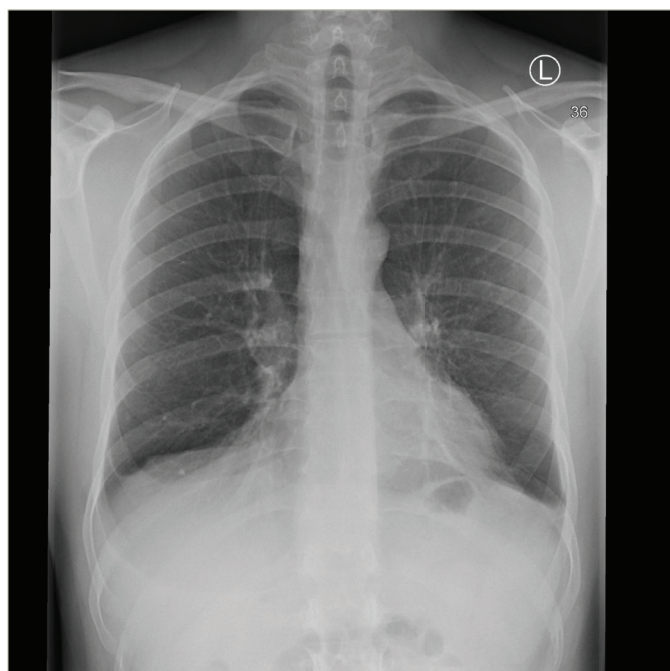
Plain radiography carried out on 3 May 2021 showing no pathological findings during the reinfection
